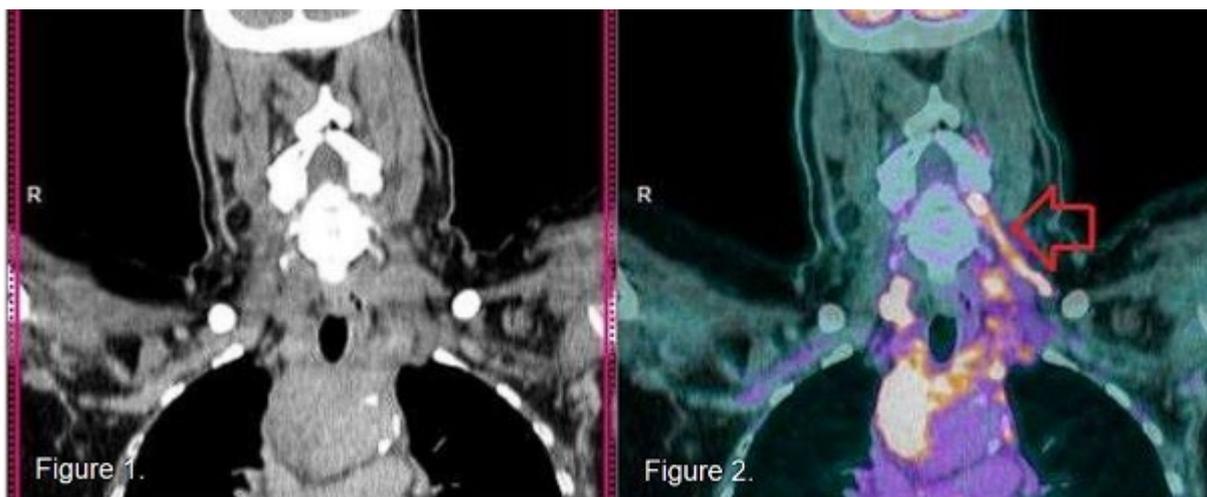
Coronal images of neck region of PET-CT. Linear FDG uptake is seen along the left lateral neck extending into the left neural and lateral aspect of the spinal canal at the level of C3-C4 and C4-C5 (red arrow).
